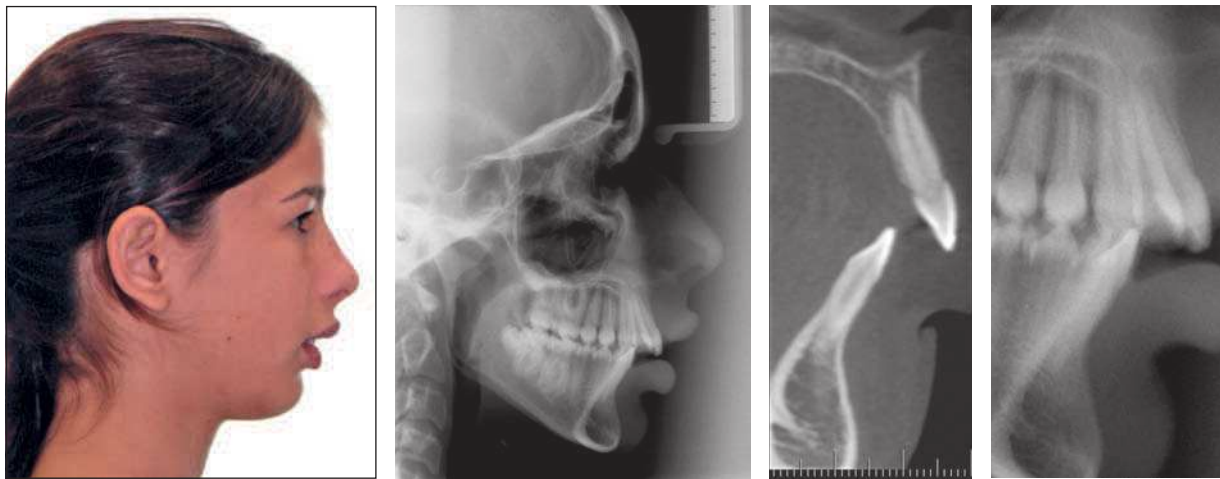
Patient with Pattern II, Class II malocclusion, maxillary protrusion, moderate mandibular deficiency, and CT scan showing more clearly the relationship of the incisors (teeth 21 and 31, image taken by sectioning the center of the clinical crown) and their respective basal bones.
